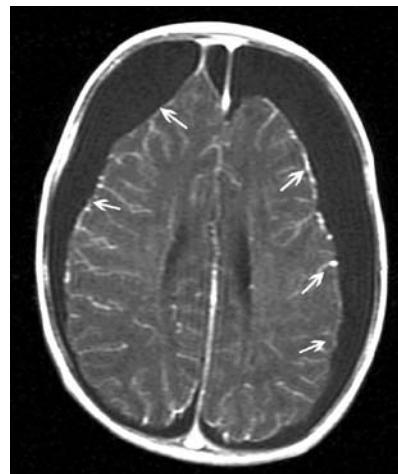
Brain CT scan showing hemorrhage and brain atrophy.
